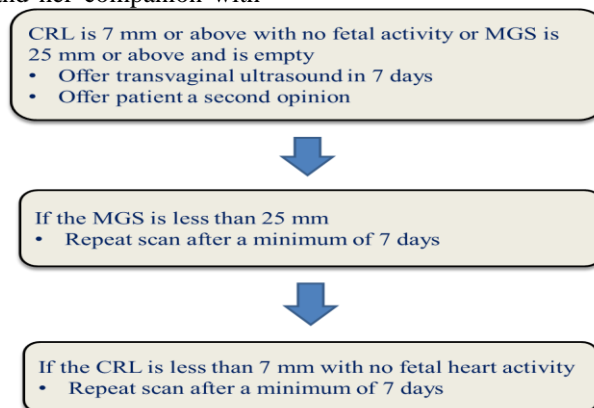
Management of miscarriage according to ultrasound finding
